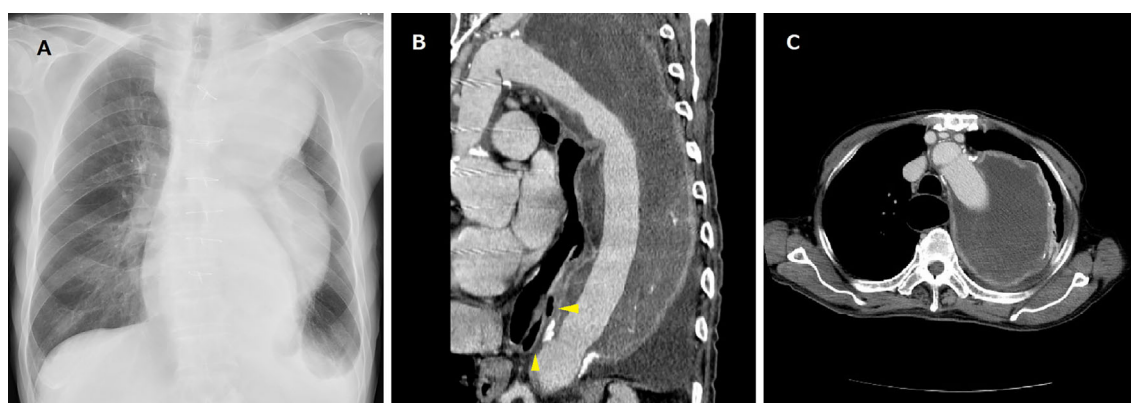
Chest radiograph (A) and contrast-enhanced CT (B, C) showing a markedly dilated thoracic aorta with ectopic gas (B, arrowheads) but without air bubbles in the aortic arch or any other signs of infection around it (C).
